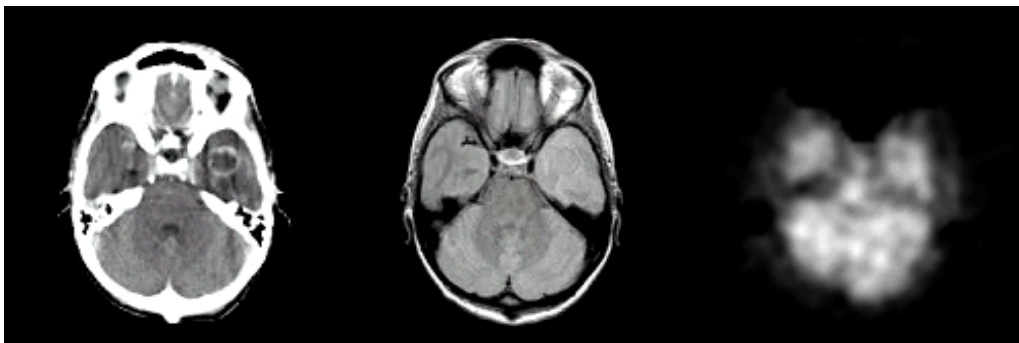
Examples of clinical images showing transverse sections of the brain. CT, MR and SPET. (from left to right)
